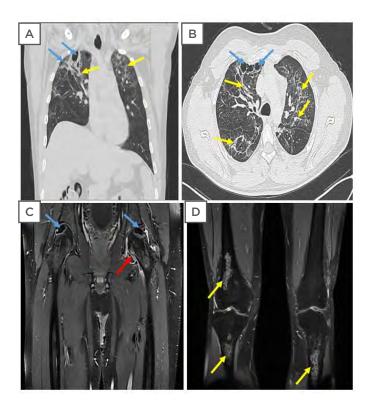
CT and MRI scans of the patient.
